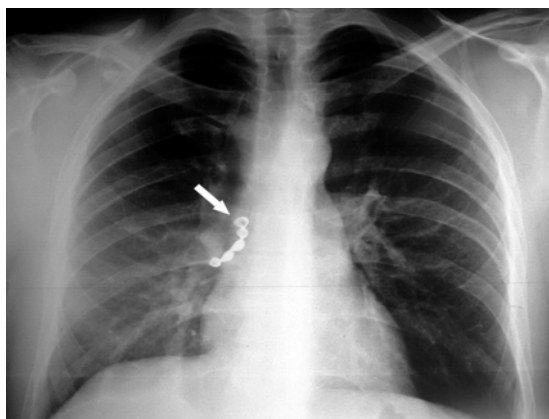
Anterior-posterior chest radiograph showed a partial denture (arrow) in the right hilum
